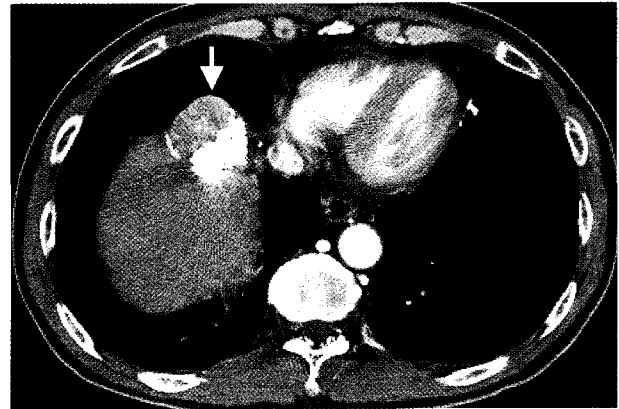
Axial image of abdomen CT scan showed partially lipiodol uptaken mass on dome of liver (arrow), suspicious for residual viable tumor.
